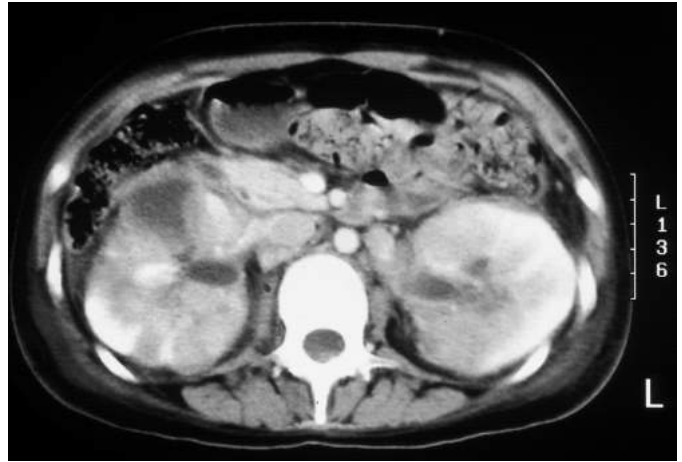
CT scan of pyelonephritis.
